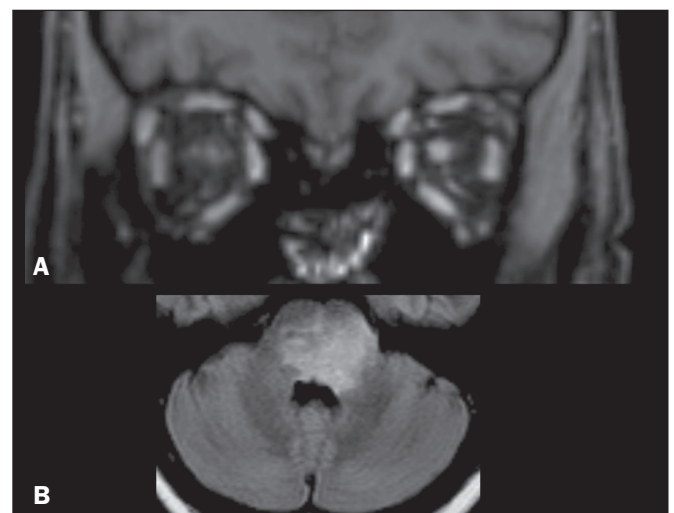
NMOSD. A: Contrast-enhanced coronal T1WI of a patient with symptoms of acute optic neuritis of the left eye showing a contrast-enhanced lesion in the intraorbital portion of the left optic nerve. B: Axial FLAIR sequence showing a hyperintense confluent lesion in the pons and in the MCPs. Note the involvement of the periventricular regions adjacent to the fourth ventricle in aquaporin-4-rich areas of the periependymal tissue.
